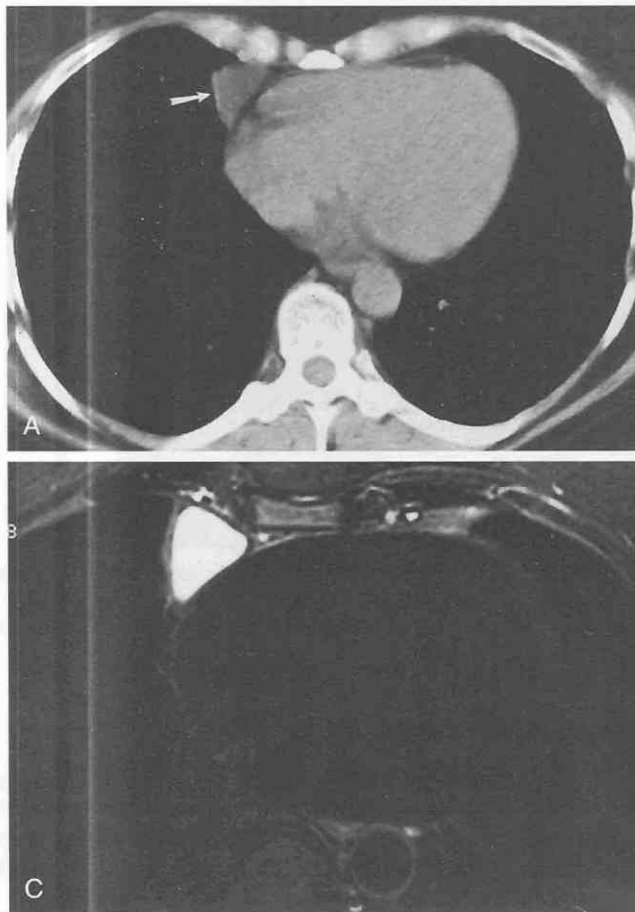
Pericardial cyst. CT (A) shows small, low-attenuation, well-circumscribed mass in the right cardiophrenic angle (arrow). MRI shows that the mass (arrow in B) is homogeneous with low signal intensity on the T1-weighted image (B) and with high signal intensity on the T2-weighted image (C). The MRI appearance is typical of a pericardial cyst.
